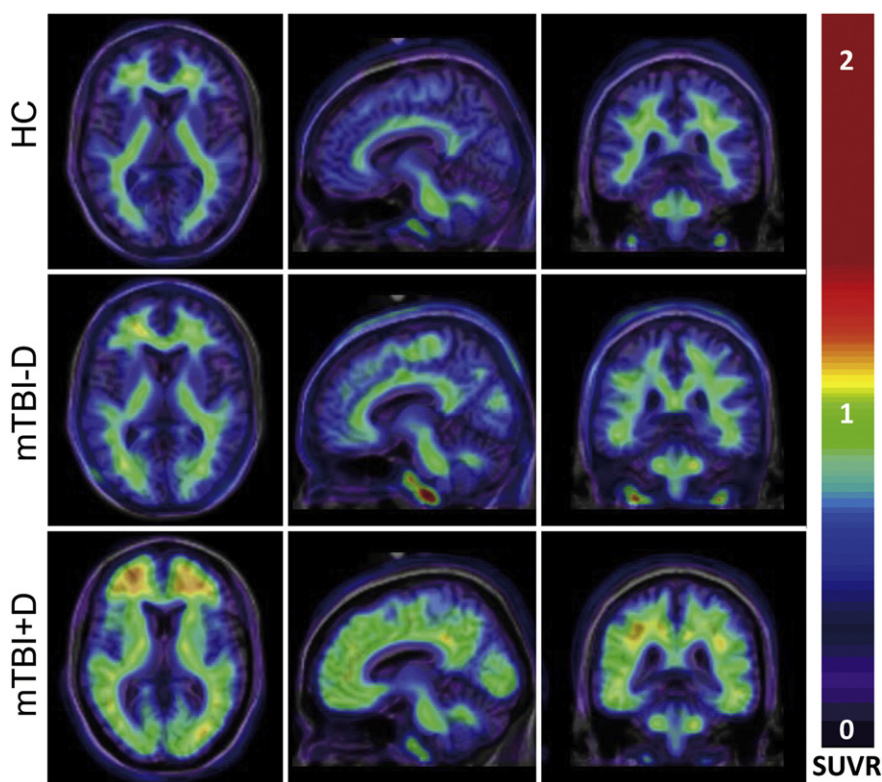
^{18}F -Florbetapir PET images in 3 subjects representative of range of tracer binding. Top subject was HC, middle was mTBI without dementia (mTBI – D), and bottom was mTBI with dementia (mTBI + D). All images were acquired with same acquisition time period, spatially normalized and overlay to the Montreal Neurological Institute MRI template in the same manner, scaled to same SUVR maximum, and were shown at identical sagittal plane for comparison.
